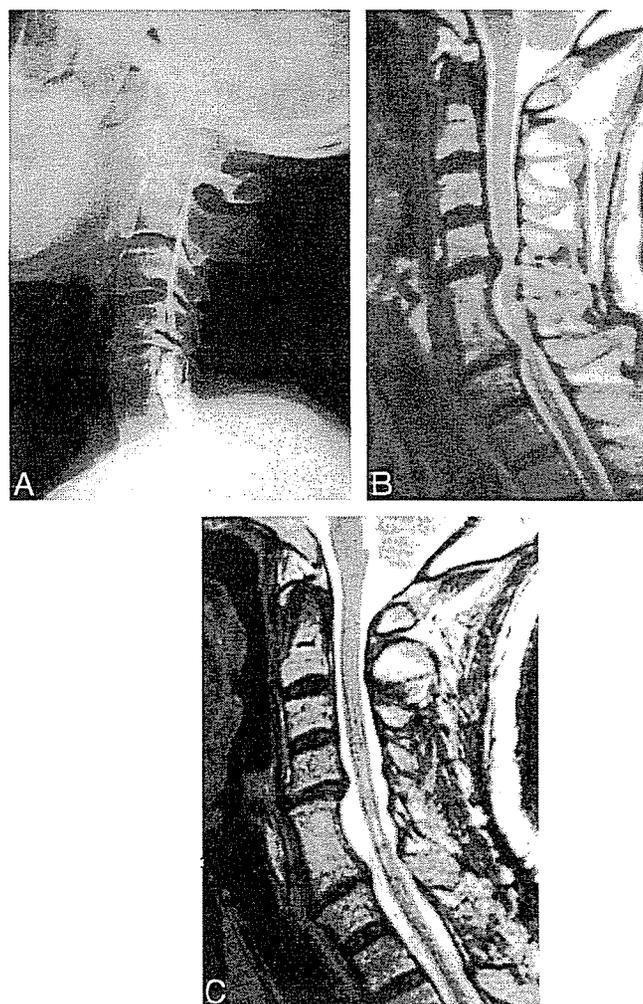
A 57-year-old man had undergone anterior cervical decompression and fusion (ACDF) at C5-C6 for cervical myelopathy resulting from soft disc herniation 17 years before. He had recurrence of cervical myelopathy and underwent expansive laminoplasty with improvement of his symptoms (clinical outcome; good). (A) Preoperative myelogram. (B) Preoperative magnetic resonance image (T2-weighted sagittal image). (C) Postoperative magnetic resonance image (T2-weighted sagittal image). Decompression of the spinal cord was good, whereas the T2 high-intensity area spread widely from the segment of ACDF to the upper and lower adjacent segments.
